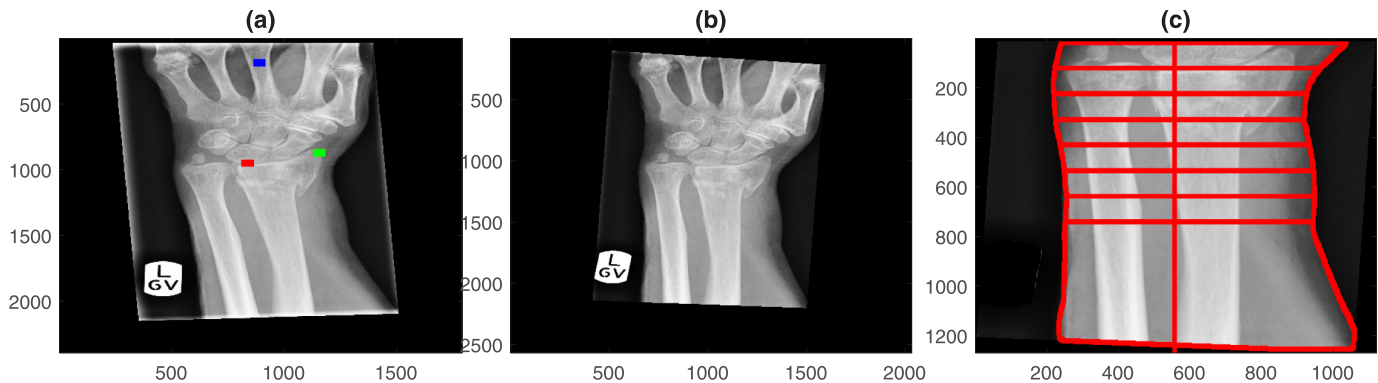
Semi-automatic extraction of measurements of the forearm. (a) Original radiograph that presents rotation of the arm and artefactual lines due to the collimator. Three landmarks have been manually located in the base of the lunate (red), radial styloid (green) and centre of the middle finger (blue). (b) Automatic pre-processing of the image where the forearm was aligned vertically and the lines removed. (c) Using the lunate landmark as a guide, the boundaries of the forearm were automatically delineated and lines traced between the boundaries. The distance between the lines is 1 cm and were being used to derive swelling measurements of the wrist.
